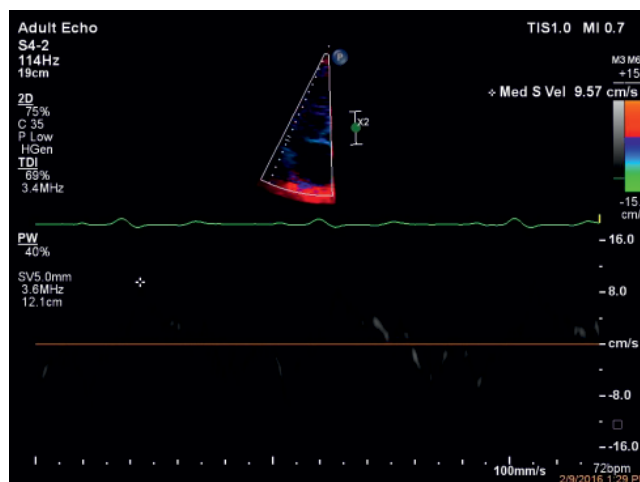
Transthoracic echocardiography, apical view, TDI, S velocity 9.5 cm/s.
